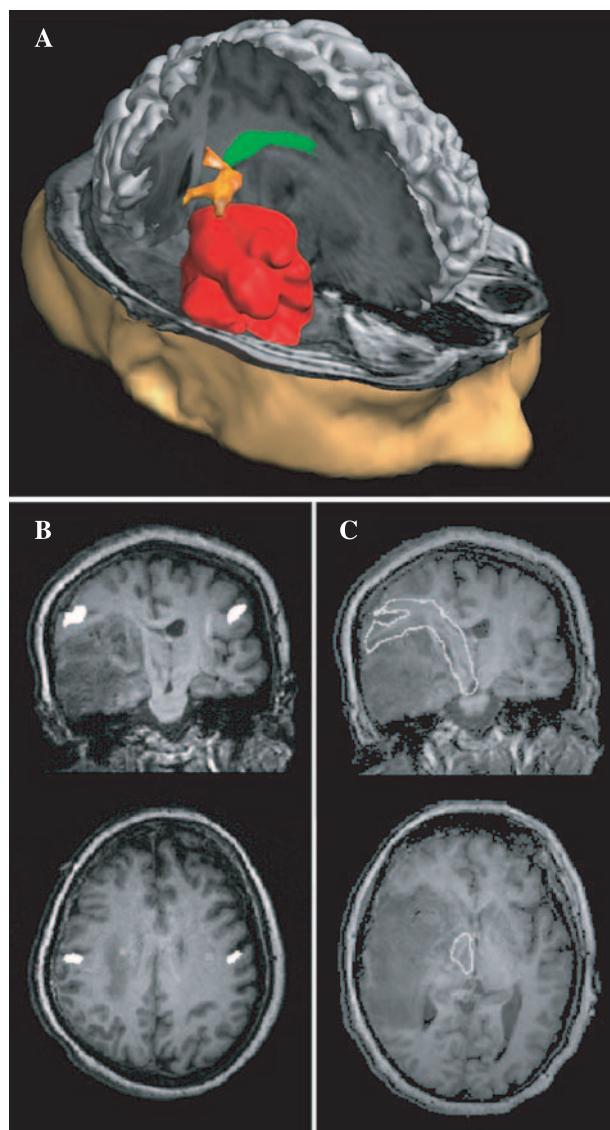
Image fusion between functional and structural MRI data (patient #3). (A) All MR information fused in a 3D view (tumor in red, tongue activations in yellow and lateral corticospinal tracts in green). (B) Tongue activations (bright white islands). (C) Lateral corticospinal tracts (bright white outlines)
